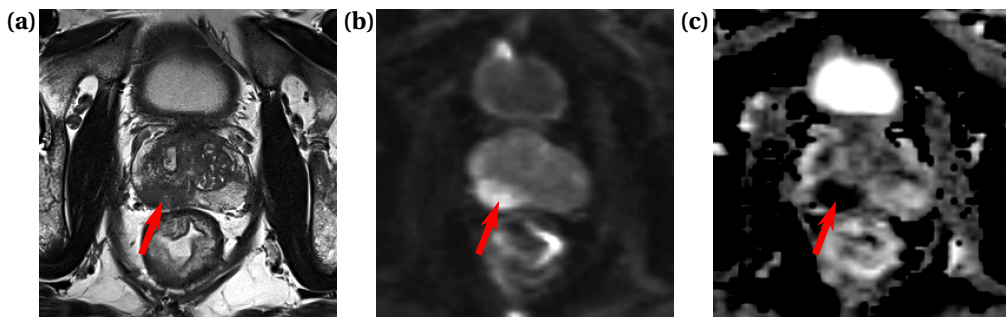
Examples of MR images used for prostate cancer diagnostics. Axial view of a (a)  $T_2$ -weighted image, (b) DWI image ( $b = 800 \text{ s/mm}^2$ ) and (c) ADC map of the prostate. The red arrows denote a PZ lesion scored as PI-RADS 5.
